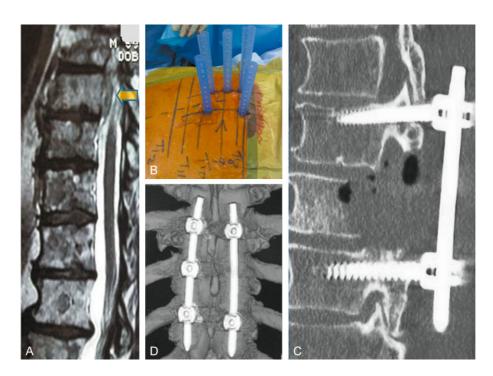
A 72-year-old man presented with a gastrointestinal stromal tumor (GIST) with multiple metastases. He developed a paraparesis rapidly over 2 weeks. (A) MRI scan image showing cord compression caused by anterior epidural disease. (B) Intraoperative photograph showing percutaneous sleeves in situ. (C) Post unilateral pediculectomy and decompression. (D) Post-operative CT scan image.
